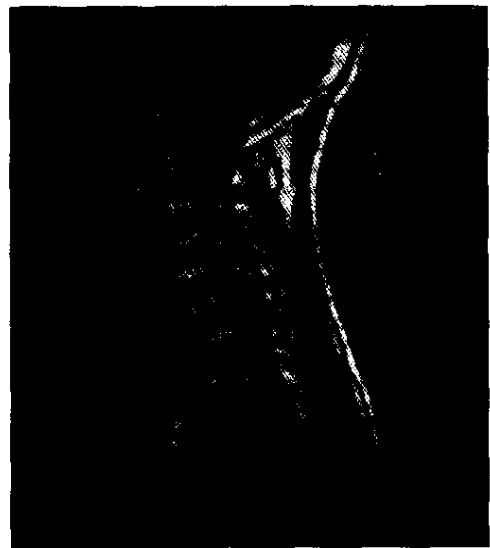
Sagittal cervical spine MRI showing the basivertebral vessels passing through the plane of fusion of the dens and vertebral body of the axis
